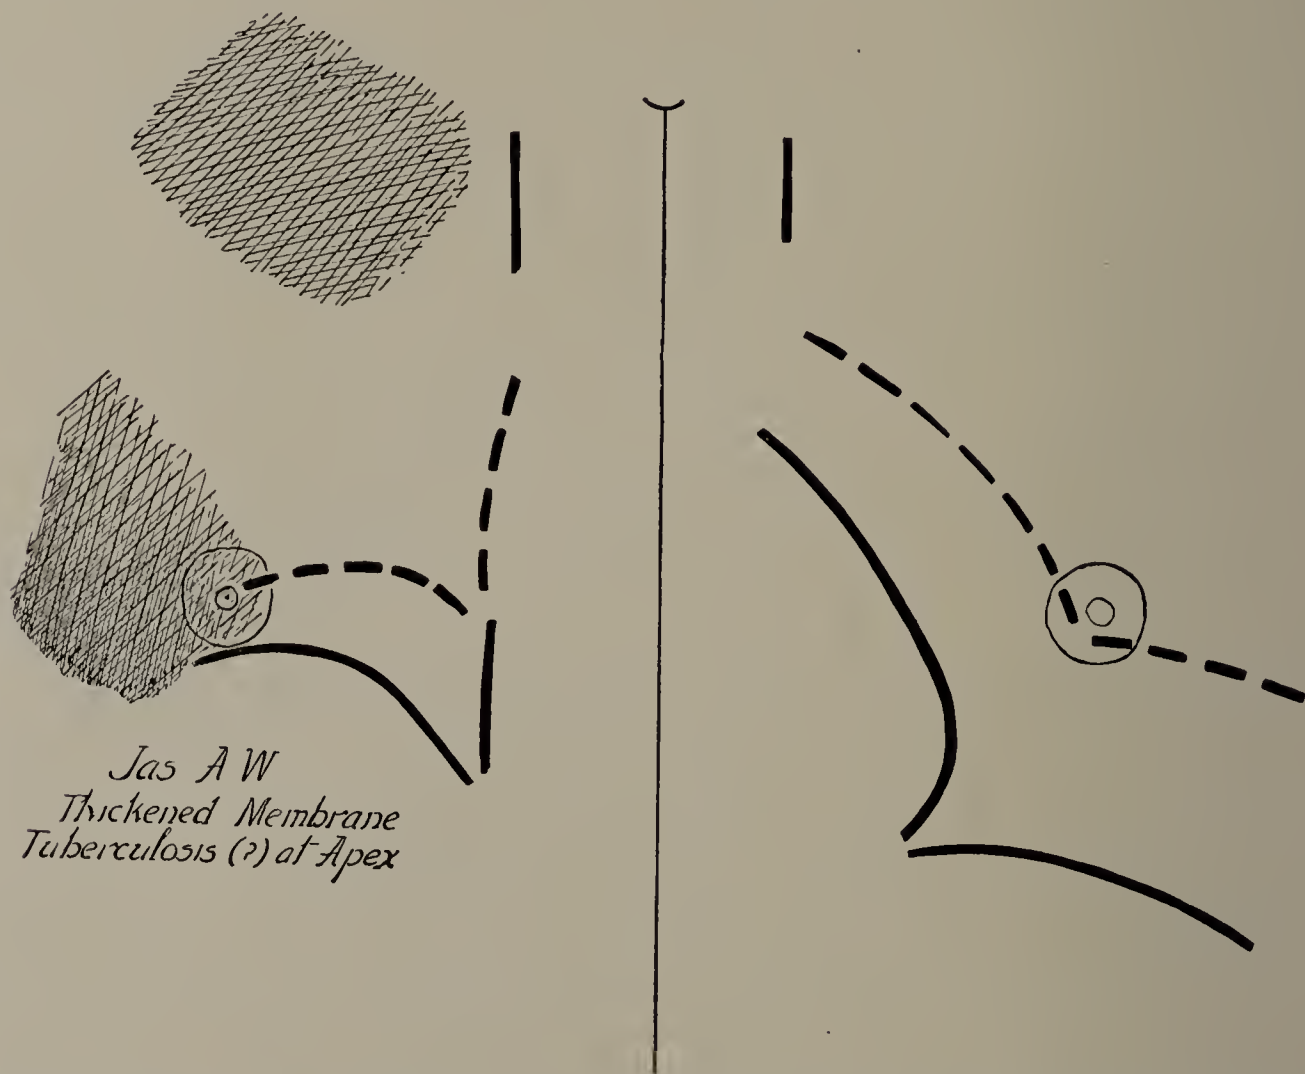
James A. W. November 2, 1899. Cut of X-ray tracing (one-third life size). Darkened area at right apex, suggestive of tuberculosis.
